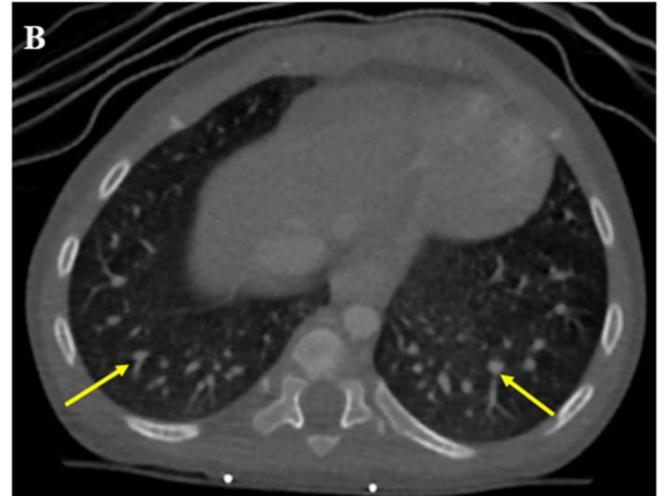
A) A CT of the abdomen and pelvis shows a connection between the right portal vein and inferior vena cava, consistent with CPSS (red arrow). B) Dilated pulmonary artery branches of the peripheral system are seen, suggestive of HPS (yellow arrow).
